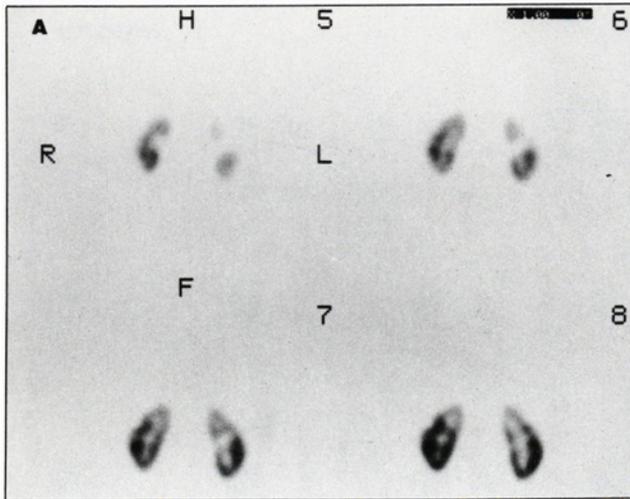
Patient 6 in whom the (3A) coronal SPECT slices suggested a peripheral scar, but a (3B) posterior view, three-dimensional rendered image demonstrated it was a normal renal crease.
